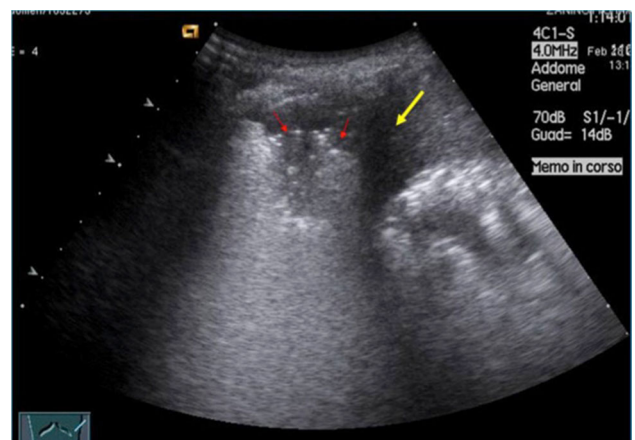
Pneumonia. Lung consolidation (red arrow) with sonographic air bronchograms consistent with bacterial pneumonia. Pleural effusion is also seen (yellow arrow)
